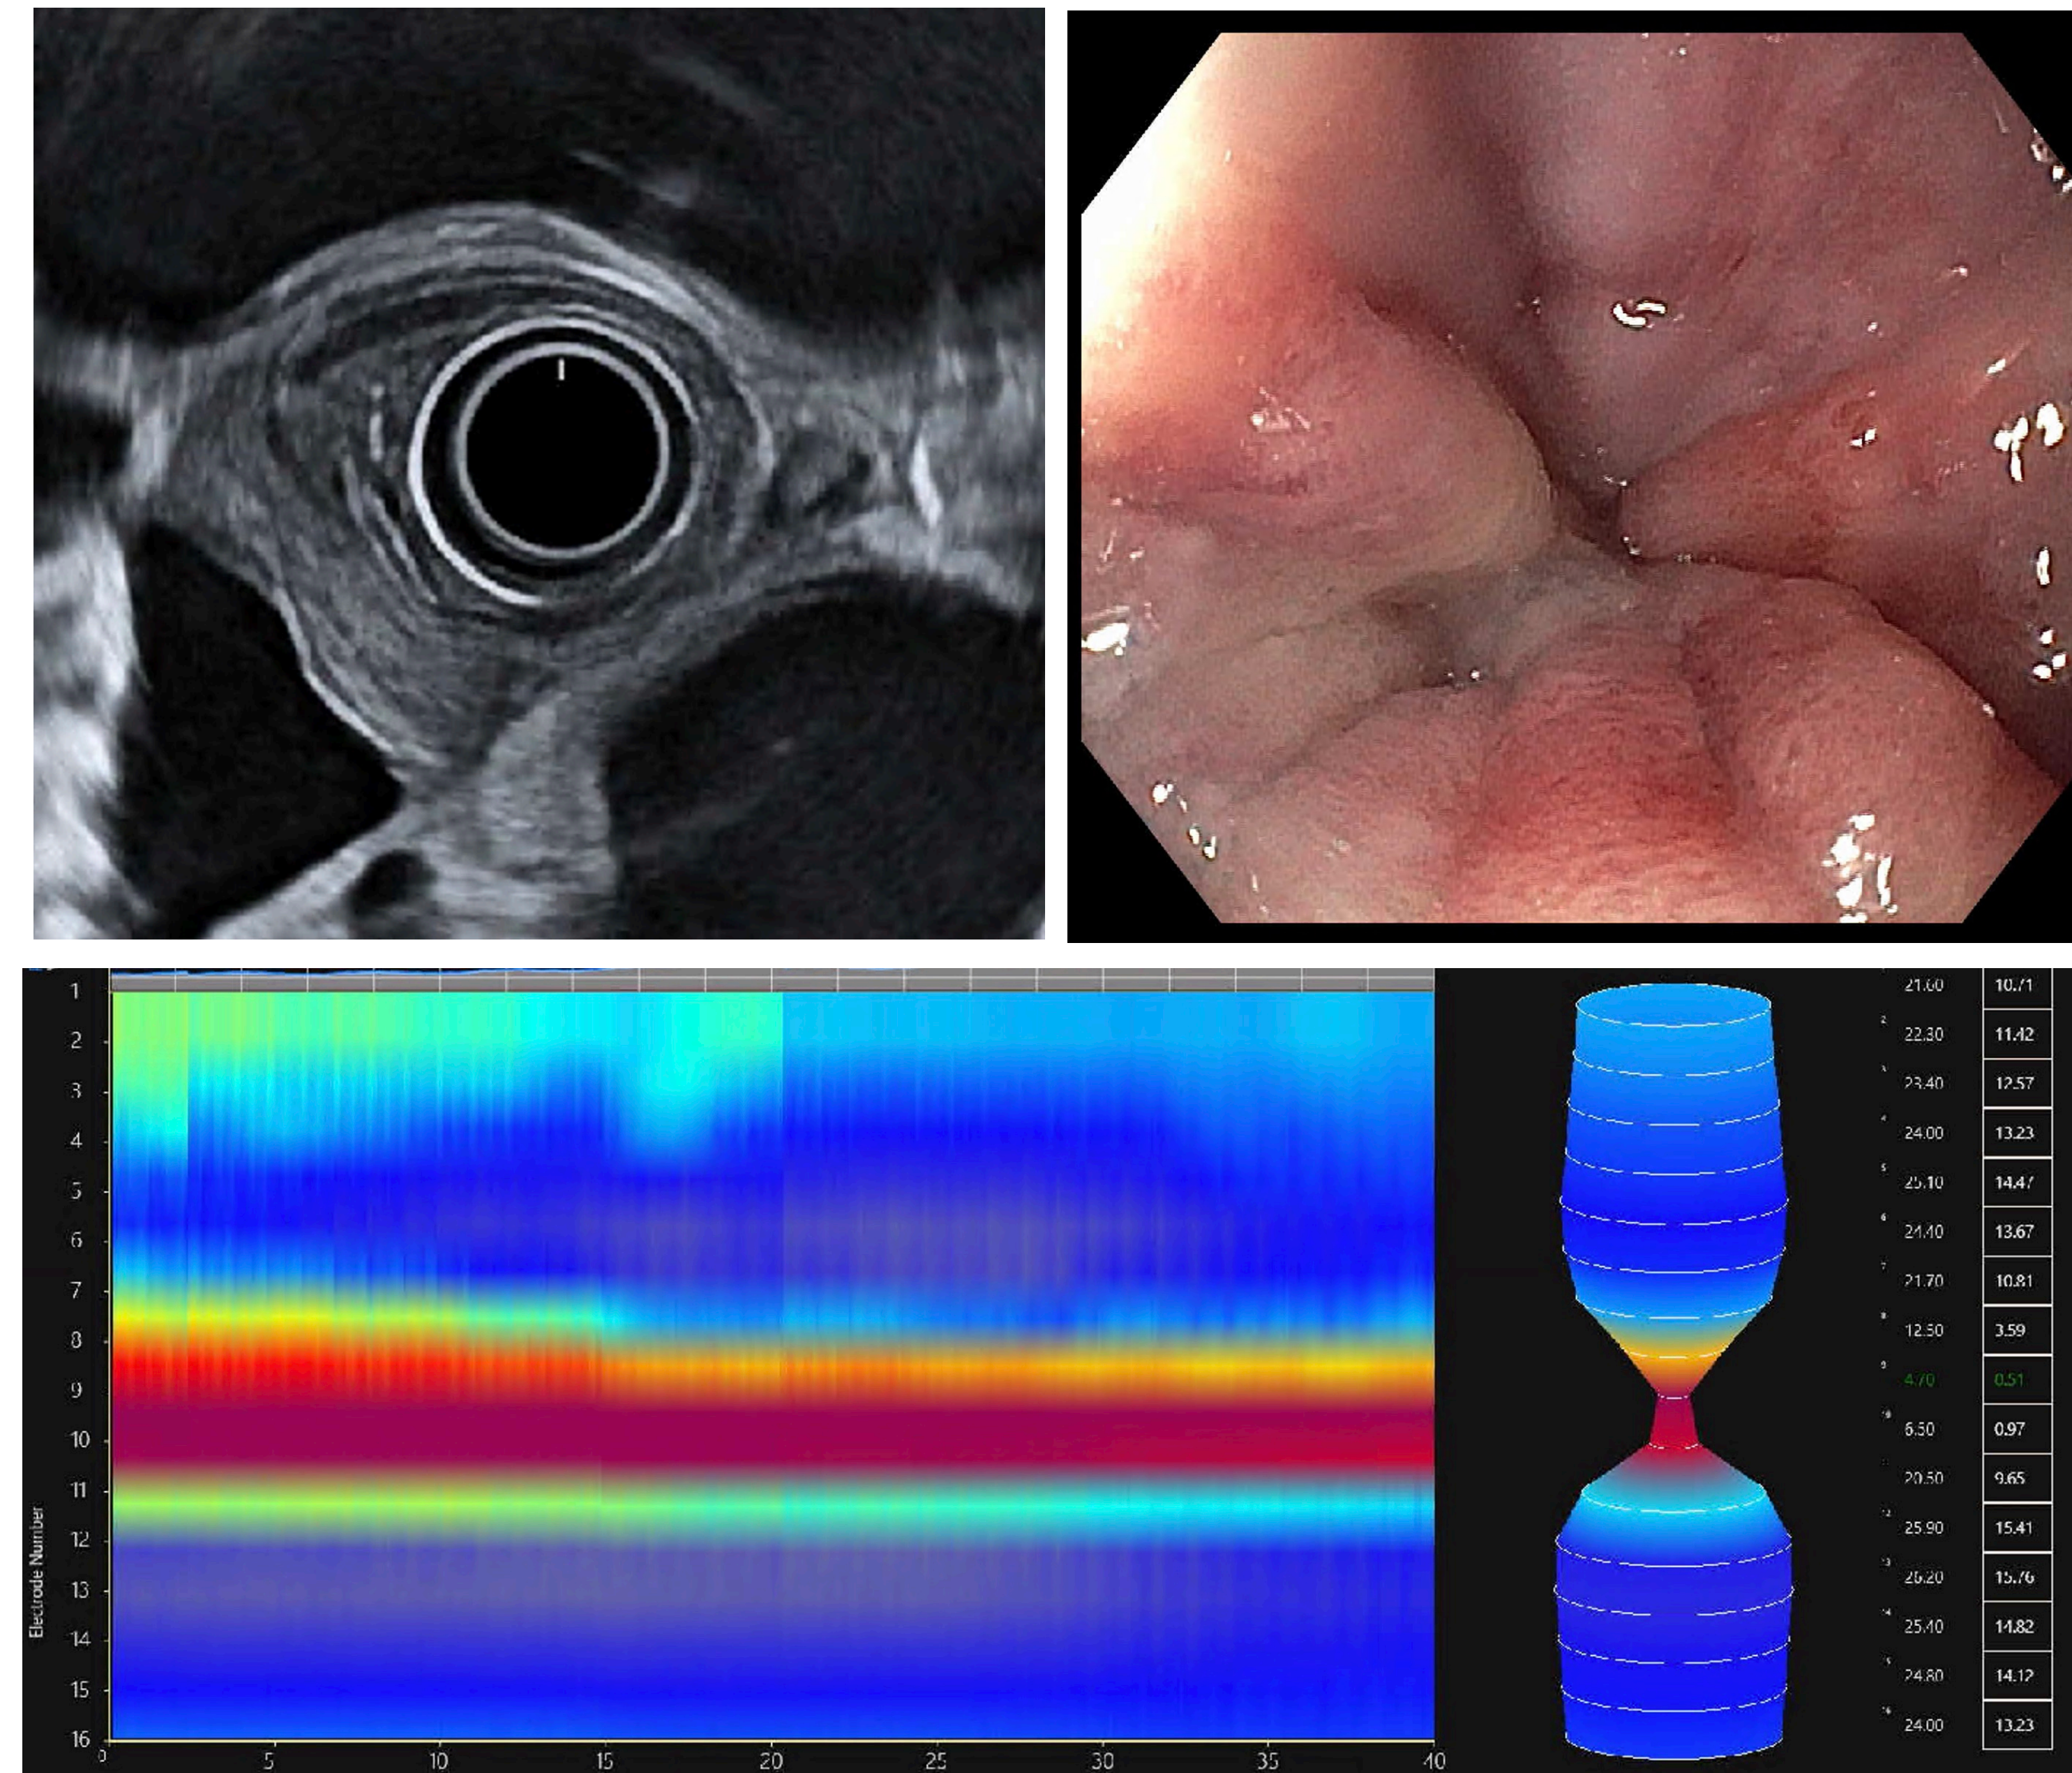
Lesion demonstrated in distal esophagus of endoscopic ultrasound (top left), white light endoscopy (top right); high-resolution manometry demonstrated persistent distal esophageal pressurization
